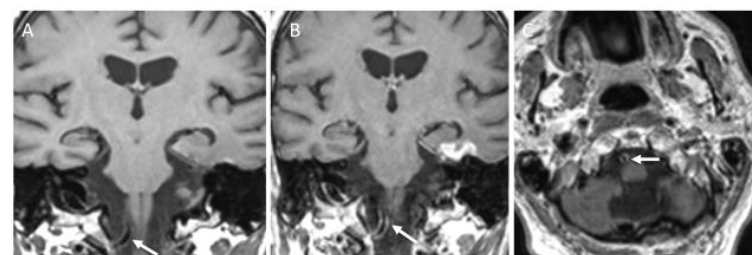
Vessel wall MRI imaging Blood suppressed vessel wall MRI coronal T1 weighted pre contrast (A), coronal T1 weighted (B) and axial T1 weighted (C) post contrast demonstrating eccentric enhancement of the medial wall of the right V4 segment VA. Vessel wall MRI can help identify active disease processes affecting the vessel wall including non-stenotic, atherosclerotic plaque and vasculitis (1,2). Purpose and summary: This
